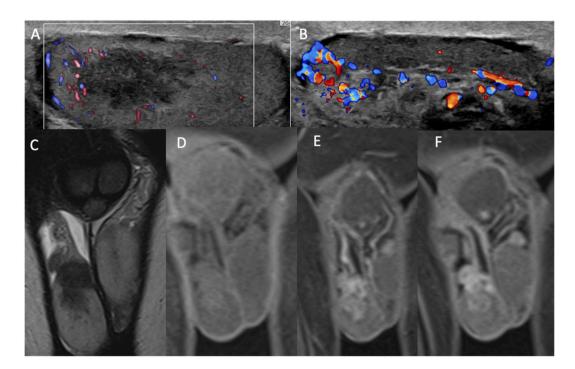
Tuberculous epididymo-orchitis in a patient with known pulmonary tuberculosis. A and B) US of the right testicle shows an ill-defined hypoechoic lesion and an enlarged epididymis with some peripheral vascularity. MRI demonstrates an ill-defined C) T2 hypointense lesion and D) T1 intermediate signal lesion with E and F) multiloculated peripheral enhancement involving the epididymal head and thick enhancing spermatic cord on the right side.
